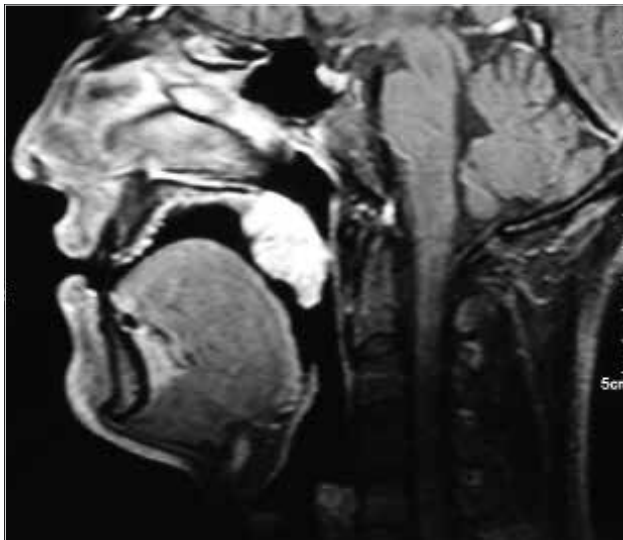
Neck MRI sagittal scanning of the patient. The lesion is visible with contrast enhancement
